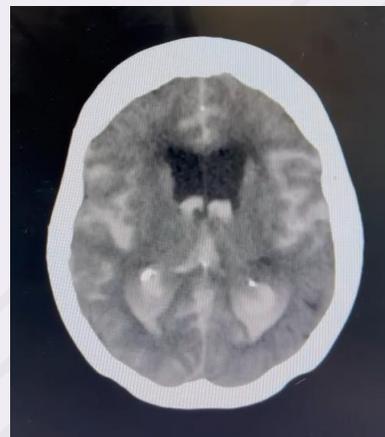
CT Brain showing extensive subarachnoid bleed with intraventricular extension
